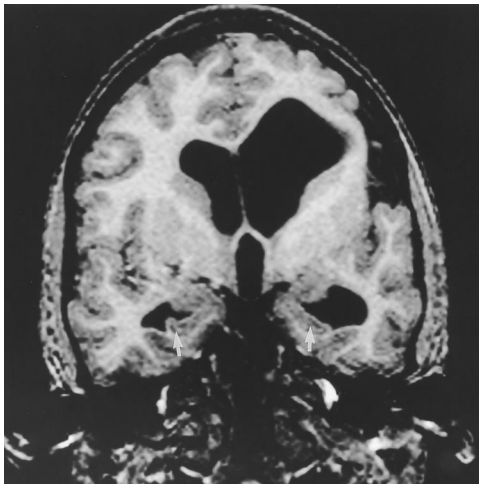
Case 20: volumetric T1-weighted MR image (20/6.2/1) in the coronal plane shows a left porencephalic cyst in the distribution of the left posterior cerebral and distal left middle cerebral arteries. Arrows indicate coexisting bilateral symmetric hippocampal atrophy.
